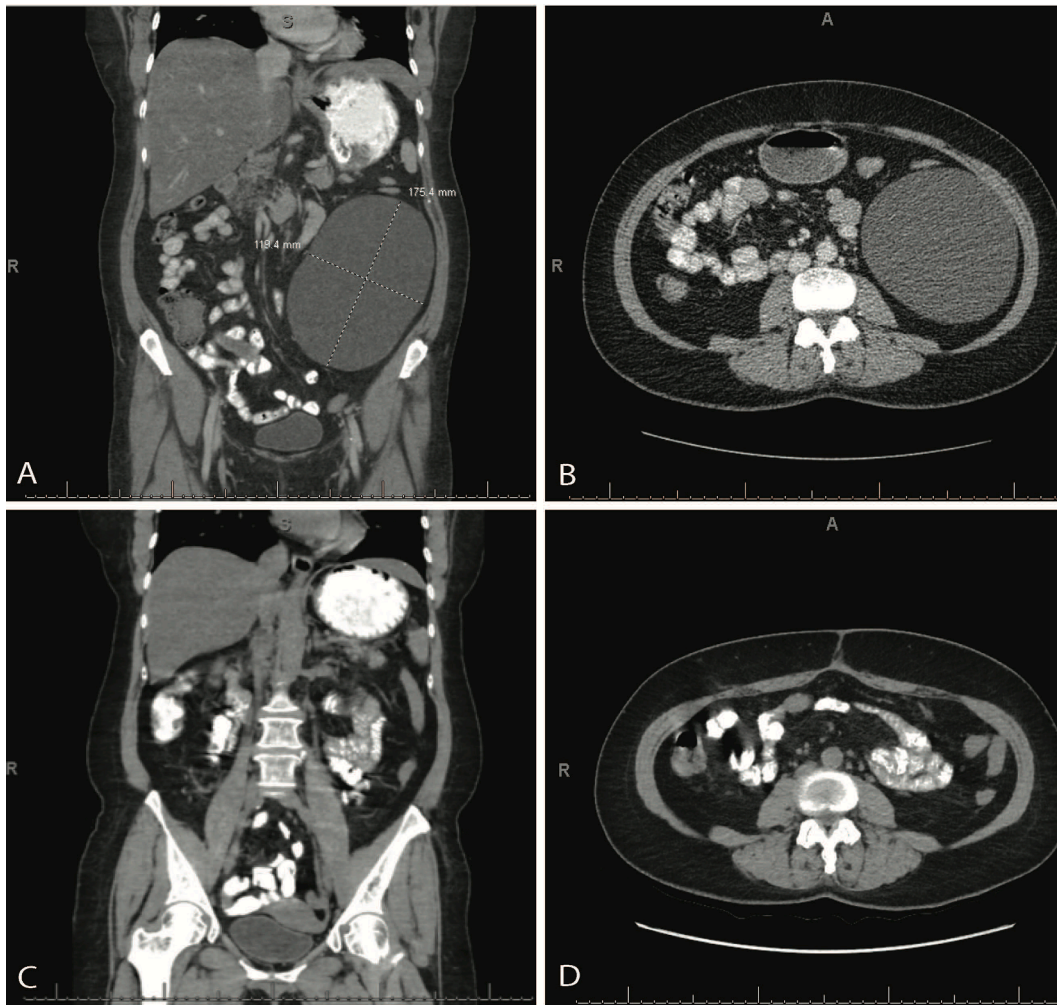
A-B Contrast-enhanced preoperative CT scan of the 18 cm fluid-filled cystic mass in the left abdomen (A coronal, B axial) concerning for potential malignancy. C-D Contrast-enhanced CT scan 7 months postoperatively demonstrating no evidence of recurrent disease (A coronal, B axial).
